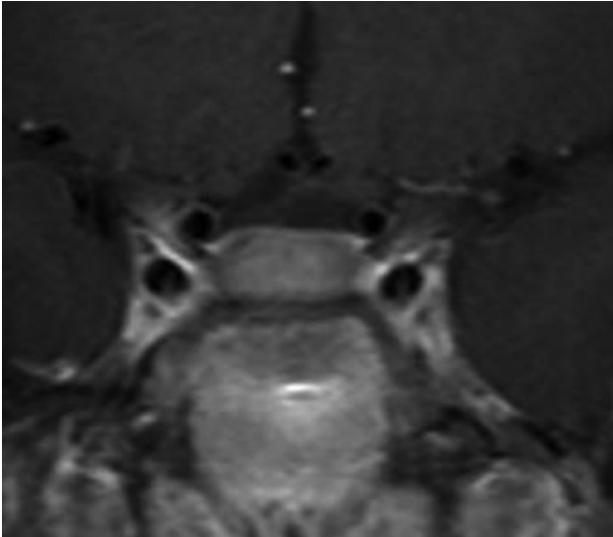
No adenoma is visible on this coronal postcontrast spin-echo pituitary MRI of a young boy with Cushing's disease, despite the fact that this MRI was performed on a 3-T MRI scanner.
